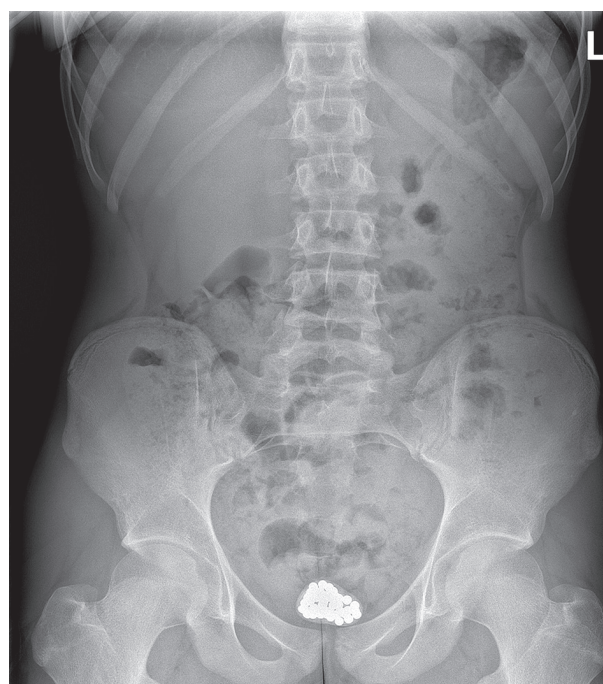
X-ray numerous spherical shading foreign bodies in bladder (Case 2)
